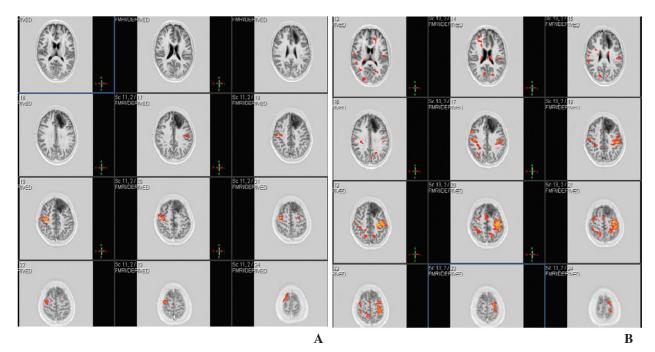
Functional MRI shows areas of stimulated brain during left hand movement (A), and right hand movement (B). There is a brain tumor in the left frontal lobe.
